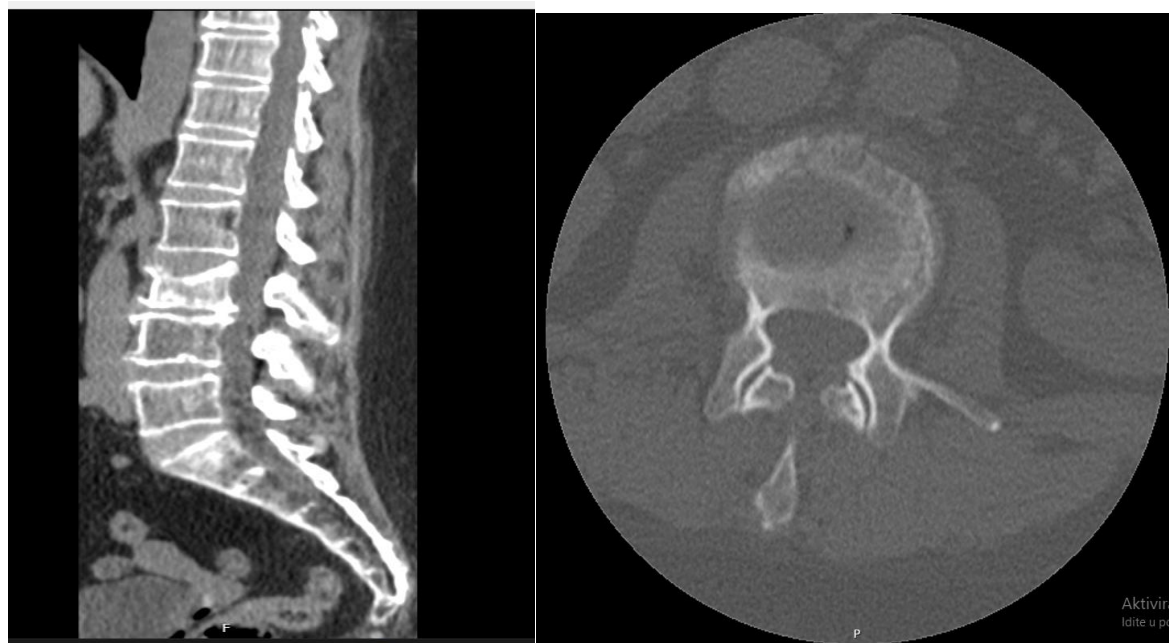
(a) Sagittal and (b) axial CT views showing a burst fracture of L3 with significant retropulsion of the vertebral body into the spinal canal and loss of body height. (Source: Croatian Hospital "Dr. Fr Mato Nikolić" Nova Bila; Radiology Department)
